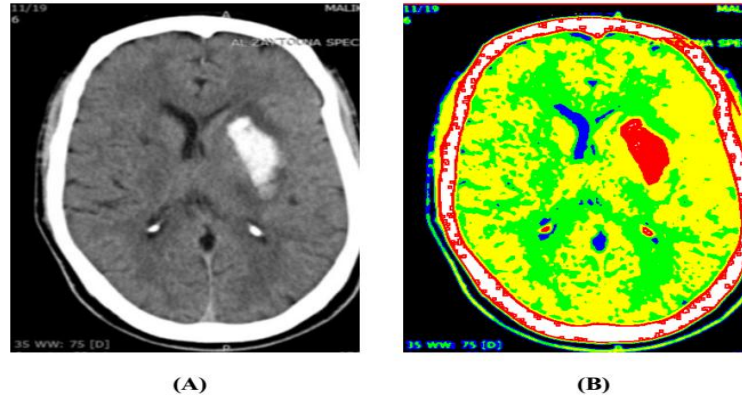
(A) The original CT image with hemorrhagic stroke, (B) Classification map based on intensity of brain tissue
